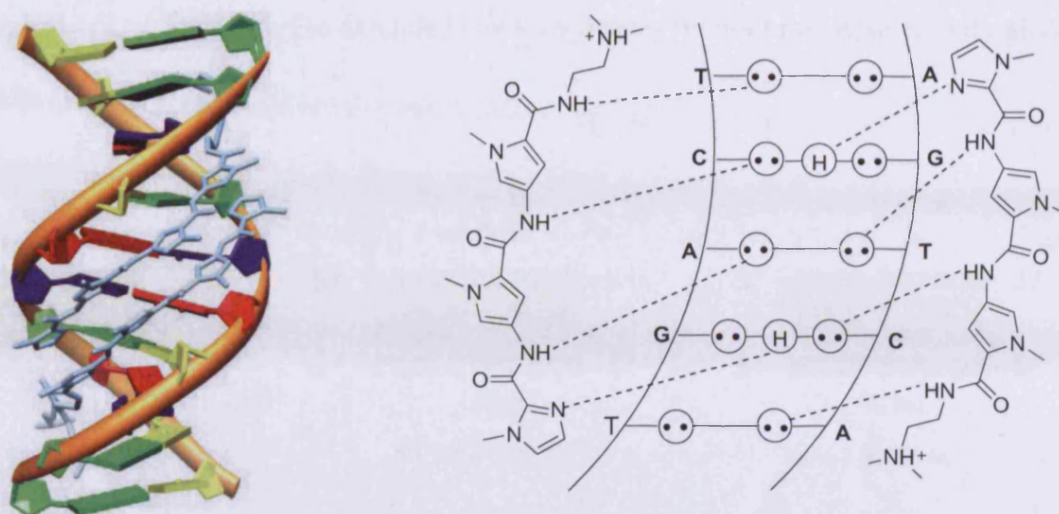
X-Ray structure (left) and hydrogen bonds view of side-by-side dimer of 2-Im-N bound to d(TGACT) (NDB ID: BDD003).
